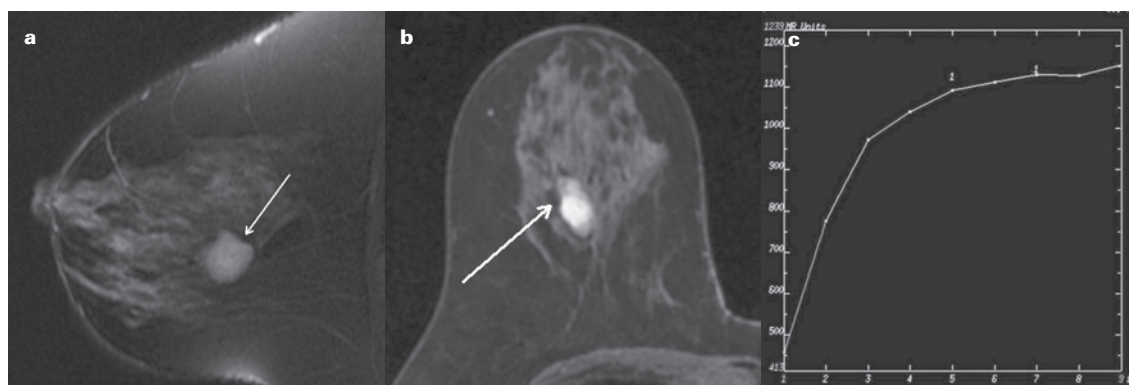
A 52-year-old woman with FAs in her right breast. The oval mass (arrow) with circumscribed margin and strong high-signal intensity on the sagittal fat-saturated T2-weighted images (a) shows heterogeneous enhancement without local rim enhancement (arrow) in the delayed phase (b) and rapid initial increase enhancement and a persistent enhancement pattern (c).
